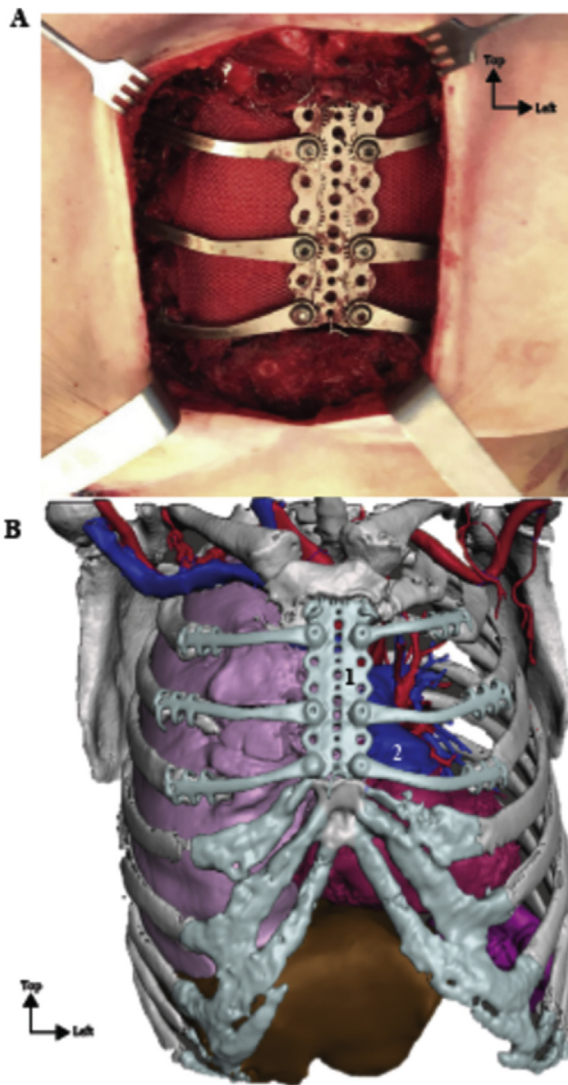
A : anterior intraoperative view according to the reconstruction with massive sternal prosthesis and Vicryl® plate. B : Modeling after postoperative CT scan in anterior view (1 : massive prosthesis, 2 : Pulmonary arterial trunk).
